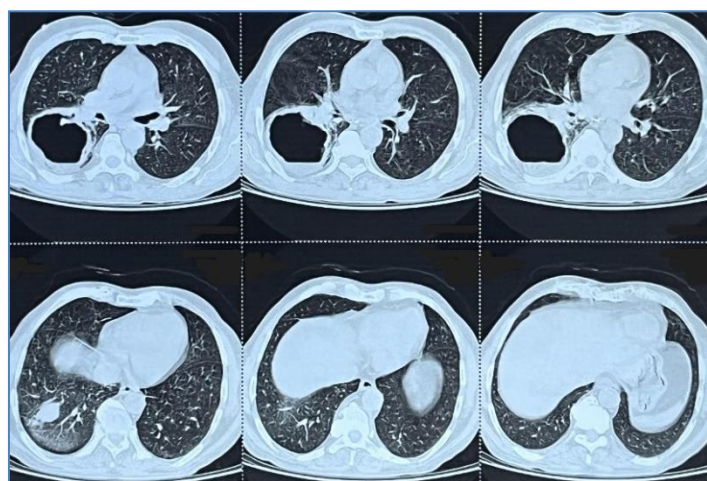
HRCT thorax showing thick-walled cavity with air fluid level in superior segment of right lower lobe
